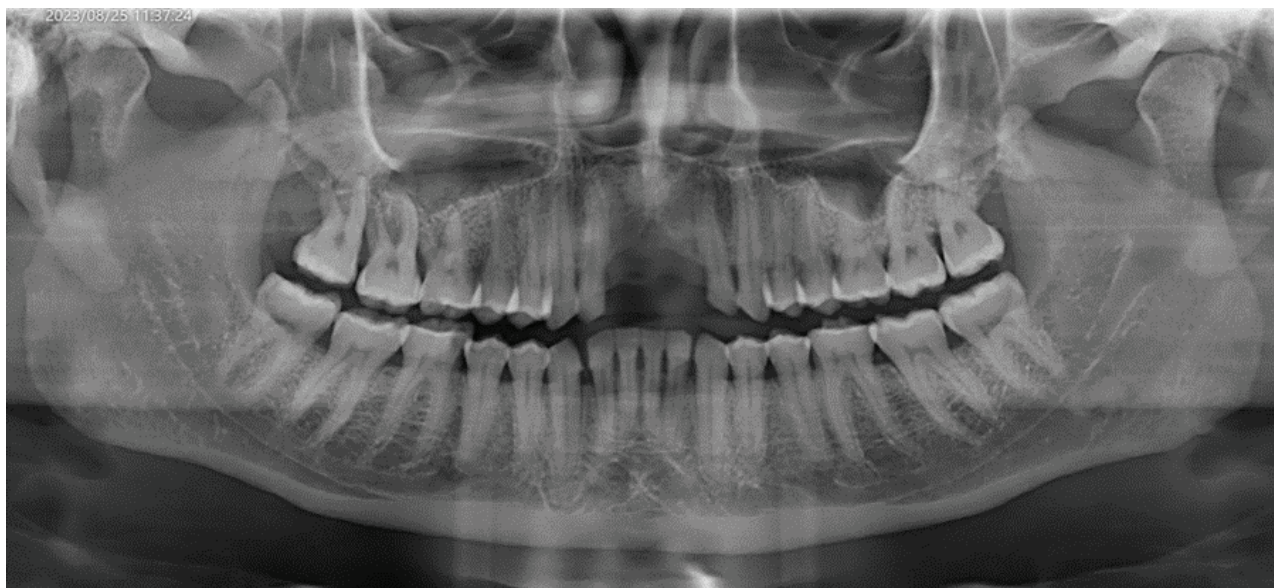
Panoramic radiographic view showing advanced loss of alveolar bone on the first quadrant around teeth 18, 17 and 16.
